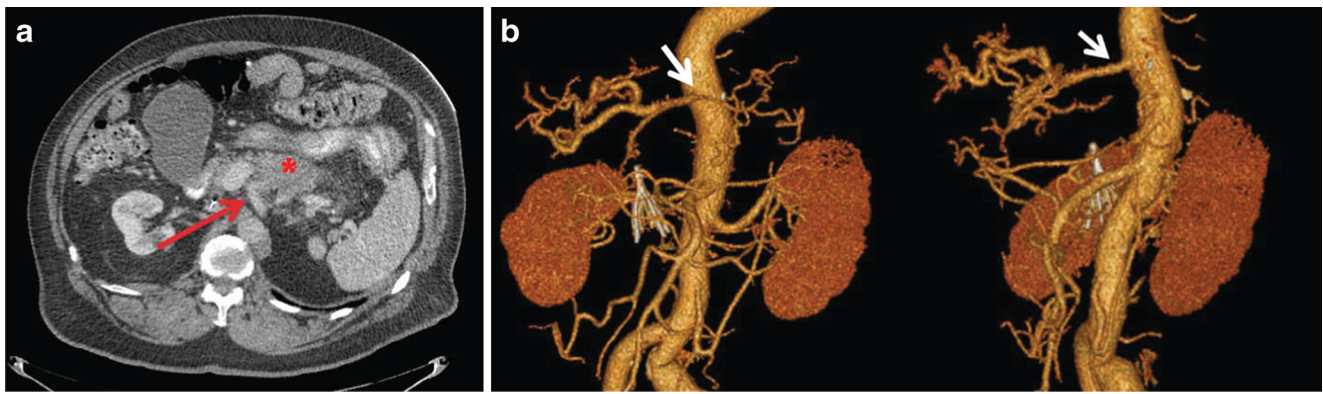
Representative imaging of case #1. a Preoperative CT imaging revealing a hypodense mass in the body of the pancreas (*) in relation to the celiac axis vessels (red arrow). b Postoperative three-dimensional CT
